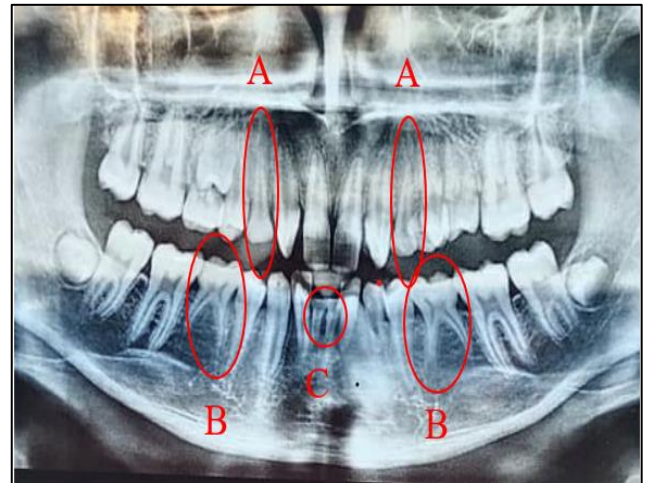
Orthopantomograph.
